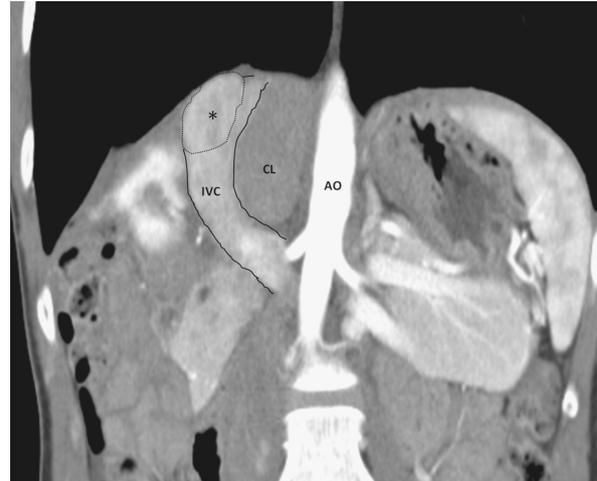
Partial resection of the dorsal side of the IVC. A CT-scan performed 3 months after resection (Patient #4) shows hypertrophy of the caudate lobe that diverts the course of the IVC, which is still patent. The asterisk (*) indicates the venous patch replacing the dorsal portion of the IVC. (AO, Aorta; CL, caudate lobe; IVC, inferior vena cava.)
